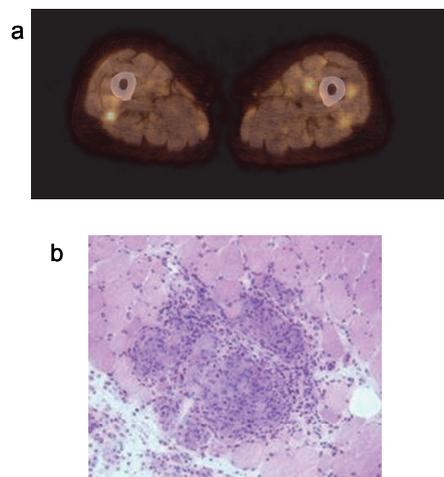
a. PET/CT image of a sarcoidosis patient showing multiple foci with increased fluorodeoxyglucose (FDG) uptake in the muscles of the lower extremities. b. Noncaseating granuloma present in a biopsy obtained from the left quadriceps muscle of a patient with sarcoidosis.
